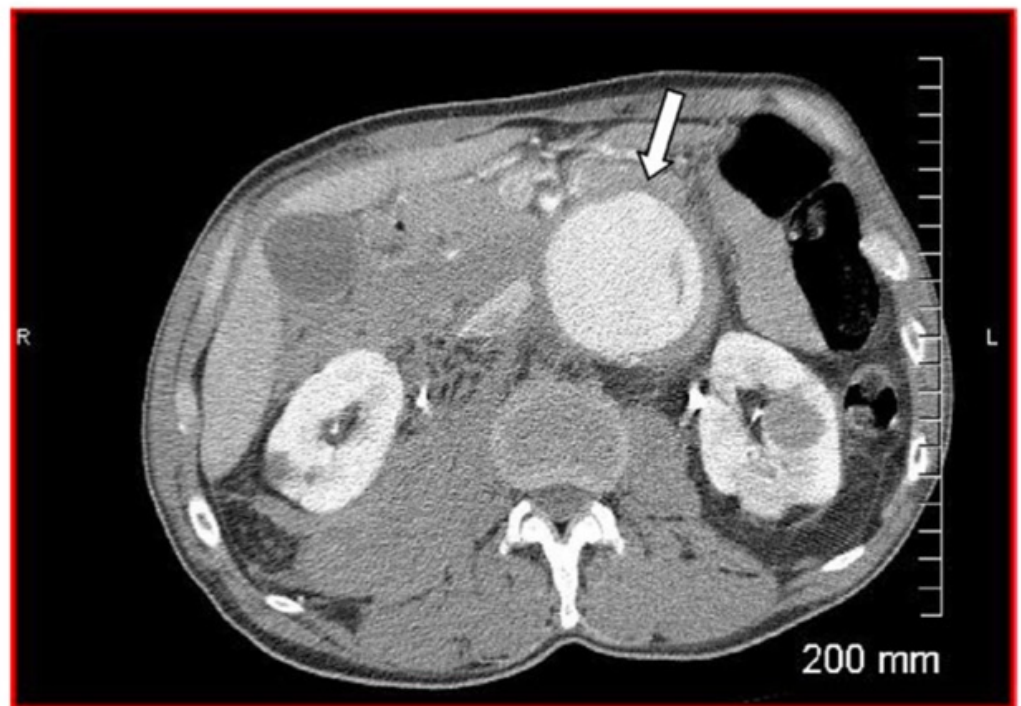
Axial CT image of the abdomen with IV contrast showing large abdominal aortic aneurysm (arrow).
